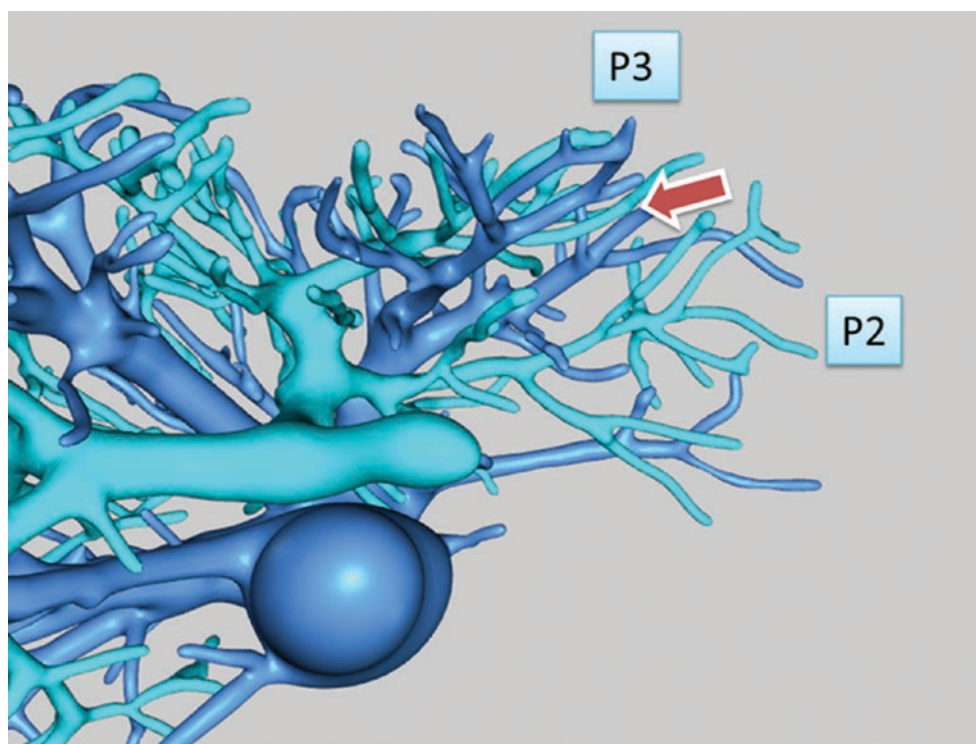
The P2 and P3 divided inside the parenchyma; it would be tricky and better to be done by experienced surgeon with intraoperative ultrasonography
